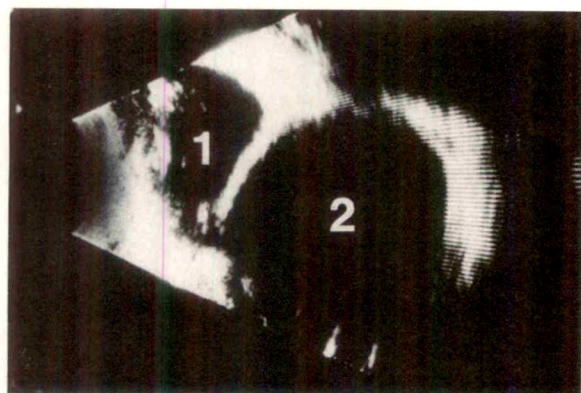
(Guterman, Abboud, and Mets). Left, B-scan of the right eye showing microphthalmic eye (1) and large cystic structure adjacent to and contiguous with the globe (2). Right, Computed tomographic scan of the orbits.
